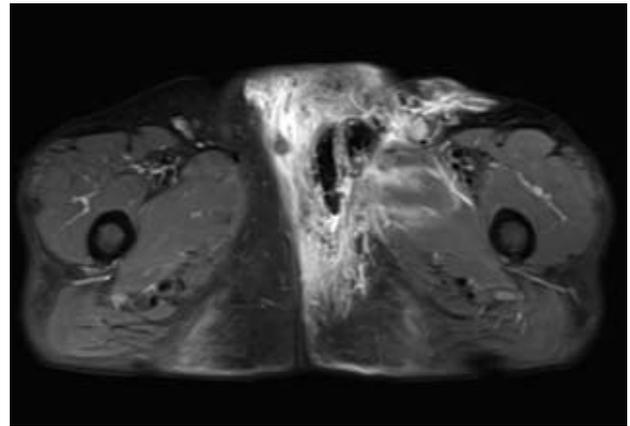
MRI on coronal plane. Hyperintensity along the fascia from the left pectineus muscle to the adductor muscle.
